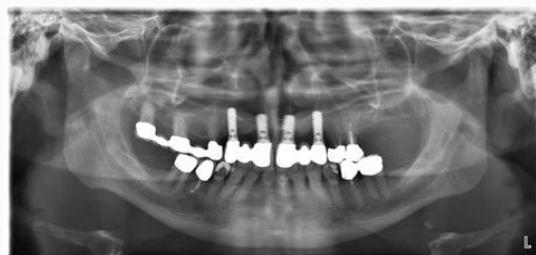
Pre-operative radiographic exam showing the bone loss around implants.
